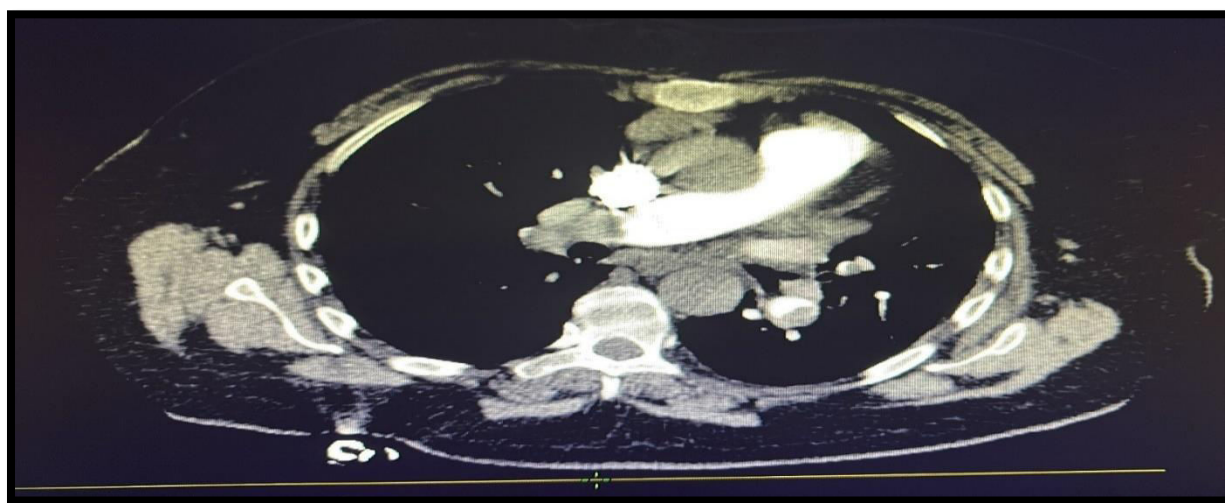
CT scan image showing bilateral pulmonary embolism
